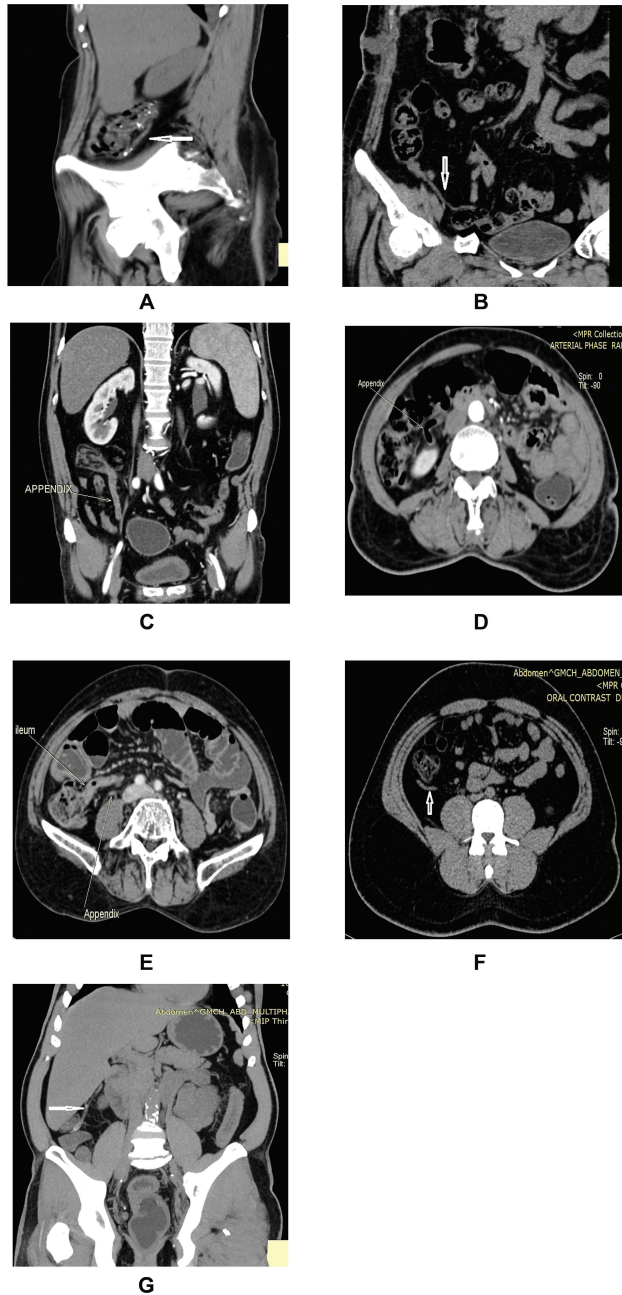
Appendiceal positions as seen on computed tomography. (A) Right (Rt) parasagittal reconstruction shows retrocecal appendix (arrow). (B) On coronal section pelvic appendix (arrow) is seen hanging over Rt iliac vessels. (C) Coronal section shows appendix in subcecal position. (D) A preileal appendix is seen on axial section. (E) Axial section shows a postileal appendix passing superiorly behind terminal ileum. (F) The paracecal appendix is seen on axial section. (G) A coronal maximum intensity projection shows appendix in subhepatic location.
